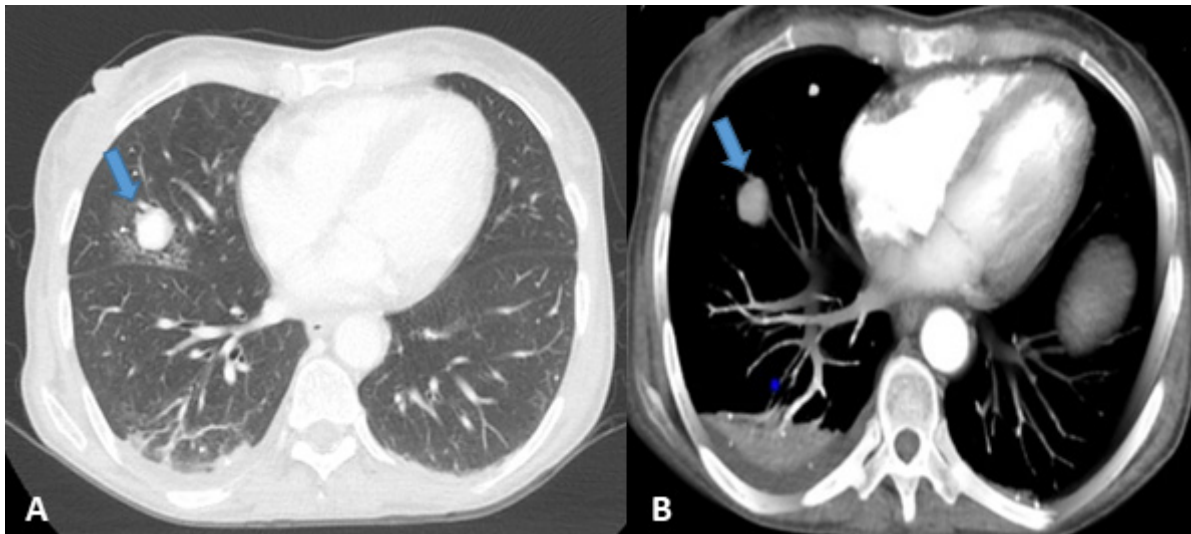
Axial view (A) and 3D reconstruction (B) of thoracic multislice computed tomography images showing a 20 mm nodular image with homogeneous enhancement after the administration of contrast located at right pulmonary inferior lobe level (blue arrow).
